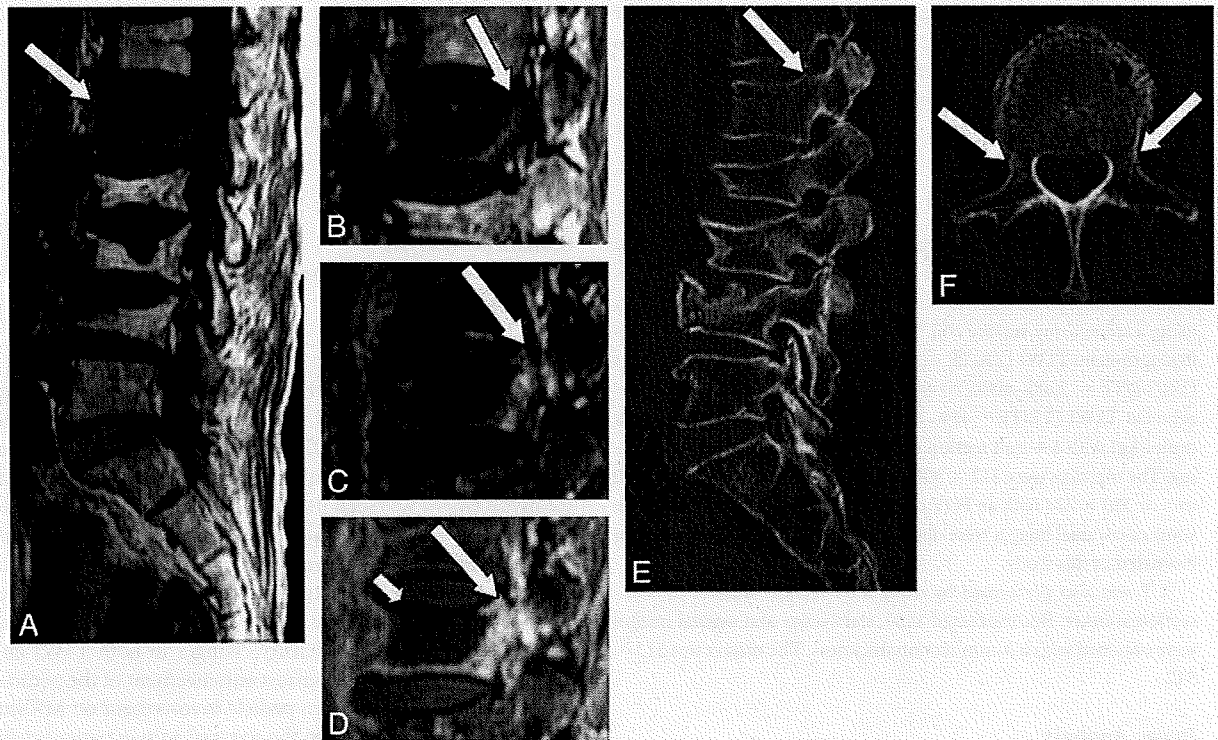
A 76-year-old woman with benign compression fracture, which occurred 1 month earlier. *A* and *B*, T1WI shows diffuse hypointensity in the vertebral body and in the left pedicle of L1 (arrow). *C*, STIR image shows heterogeneous hyperintensity in these areas (arrow). *D*, Contrast-enhanced T1WI shows marked enhancement (arrow). A large area of low signal intensity indicates necrosis or cleft (small arrow). *E* and *F*, On sagittal (*E*) and axial (*F*) CT scans, there is no apparent abnormality in the pedicle (arrow).
